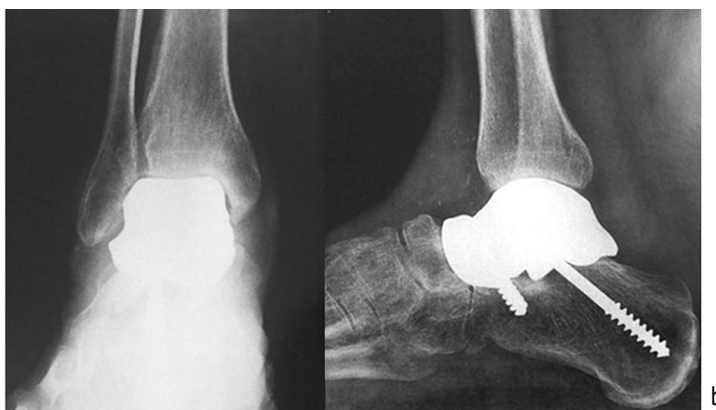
Talus implant, ventral view, hydroxyapatite coating used for subtalar arthrodesis is visible on the caudal surface of the implant (a) [73]; b control radiographs 2 years after the operation
